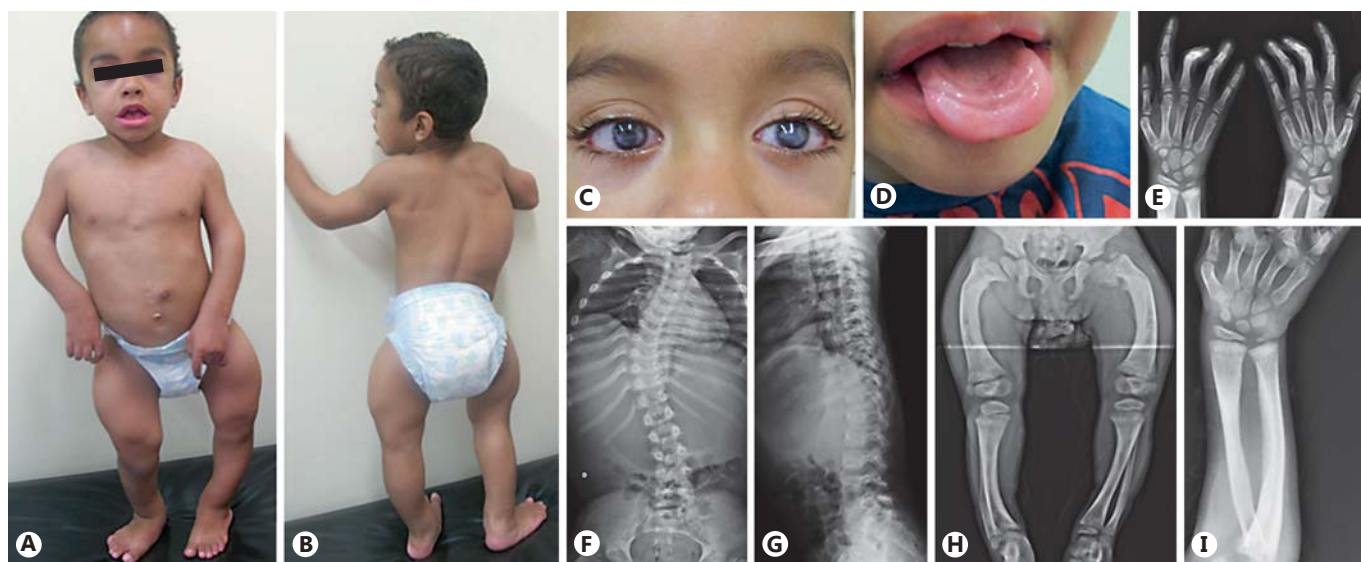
Clinical pictures and X-rays of the patient at the age of 5 years. A, B Frontal and dorsal views of the patient showing large joint restrictions, bowing of the lower limbs, and scoliosis. C Bilateral corneal opacity. D Smooth tongue. E Hand X-rays showing
